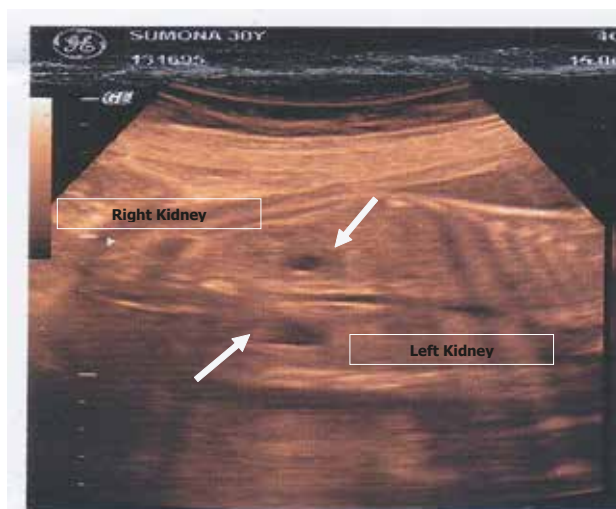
Longitudinal ultrasonography scan of 34 weeks gravid uterus shows sonolucent area (Black Spot) is dilated renal pelvis over both kidney
